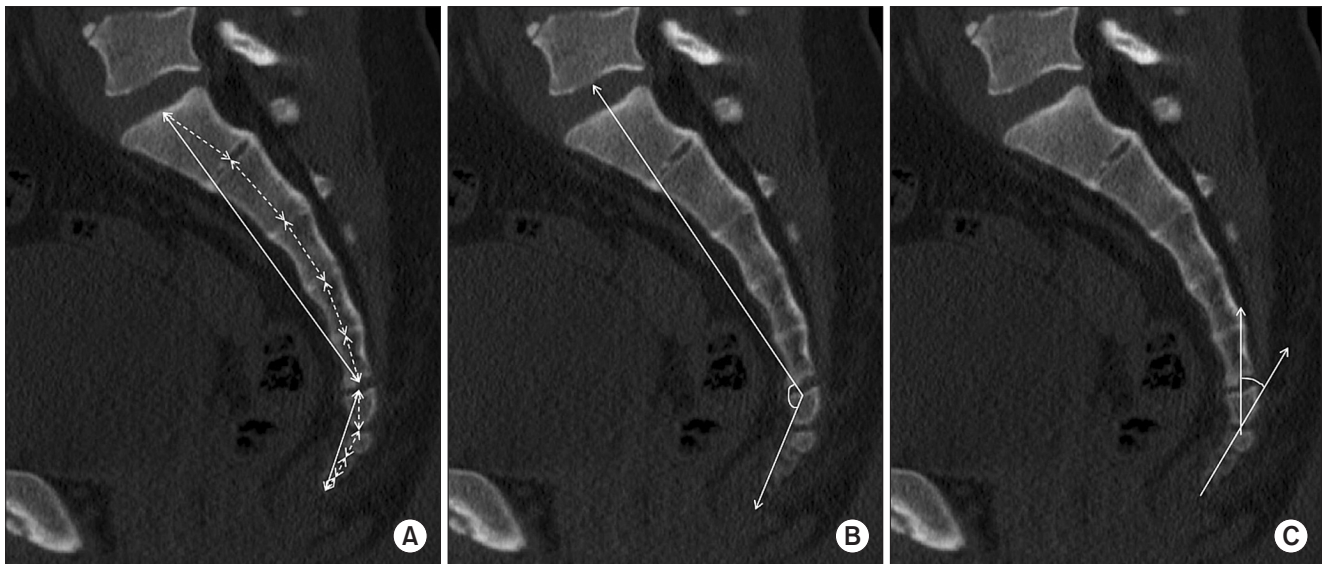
Computed tomography images for morphometry of the sacrococcygeal region. (A) Straight (solid line) and curved (dotted line) lengths of each sacrum and coccyx. (B) Sacrococcygeal angle. (C) Intercoccygeal angle.
